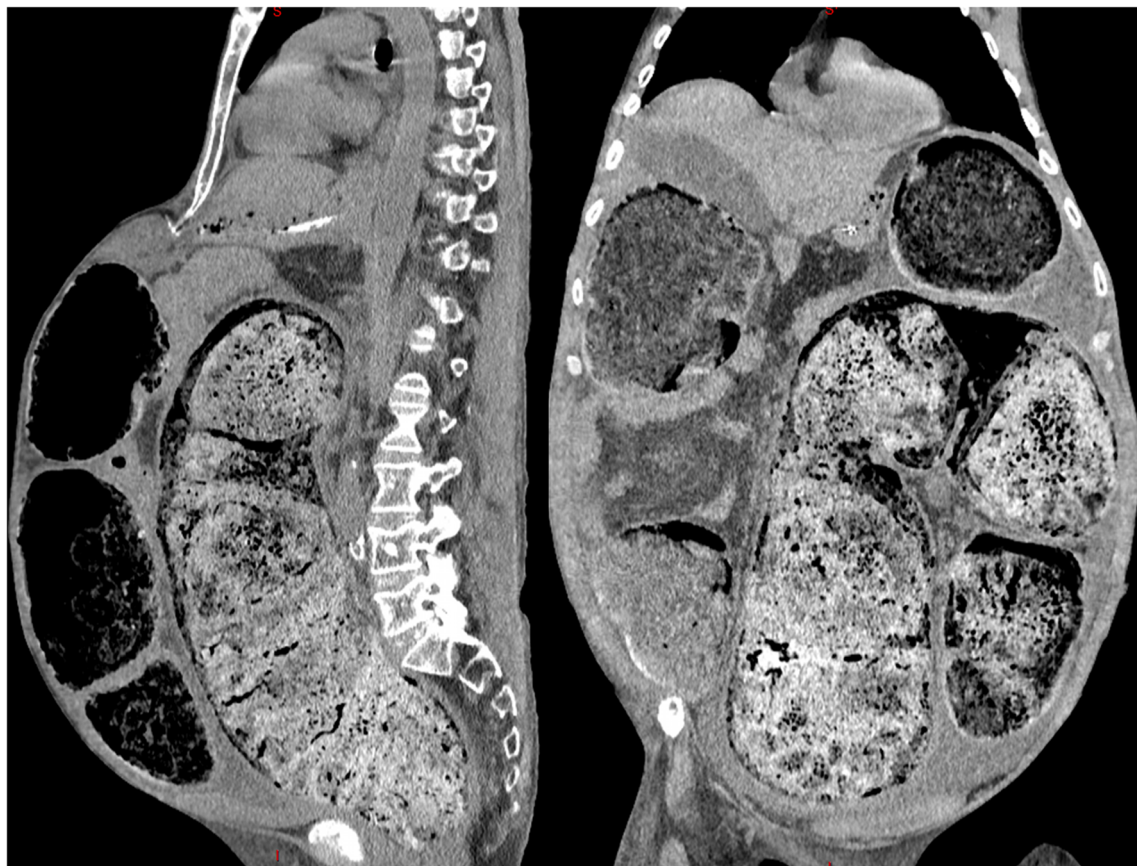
Sagittal (left) and coronal (right) views of the abdominal computed tomography revealing a severe fecal impaction
